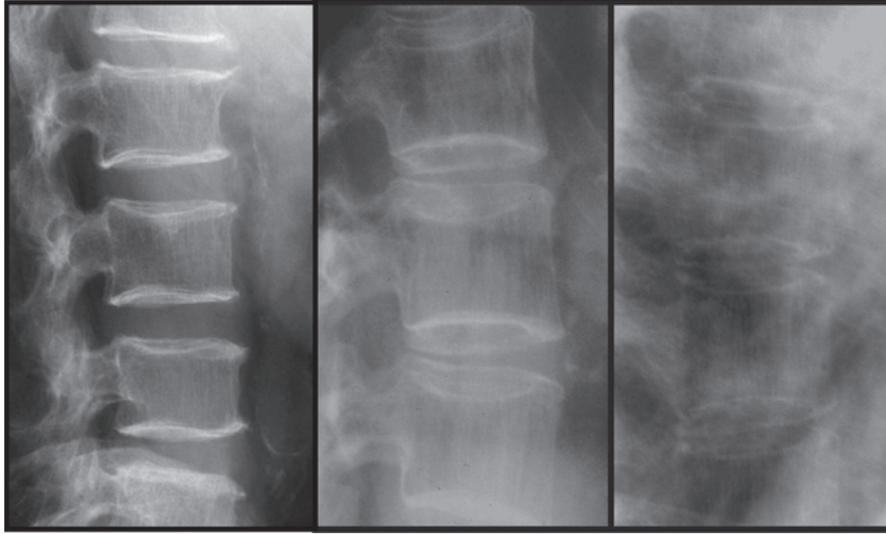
(Left) General decreased visual bone density results in increased radiolucency of the vertebrae with relative accentuation of the cortical rim, or “picture framing.” (Center) Increased vertical striation owing to the proportionally greater loss of horizontal trabeculae and compensatory hypertrophy of the vertical trabeculae. (Right) Severe osteoporosis: the vertebrae can hardly be distinguished on the lateral lumbar spine radiograph. There are multiple endplate and compression fractures.
